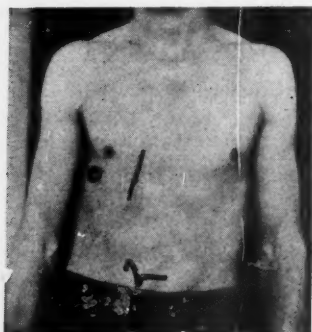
Case 13: The small circle marks the healed wound of entrance of shrapnel fragment that lodged within the pericardium at the base of the heart. The fragment was removed through a parasternal incision on January 23, 1942, the injury having occurred on December 7, 1941.
